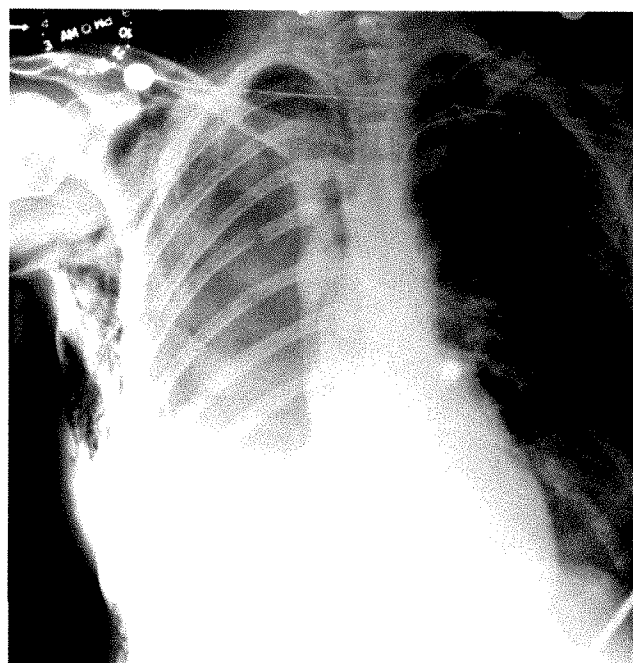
Chest roentgenogram taken on the second postoperative day. The appearance of the thoracic contents is typical of a post-operative right pneumonectomy. The heart has returned to the normal position. There is a pleural effusion on the right.
